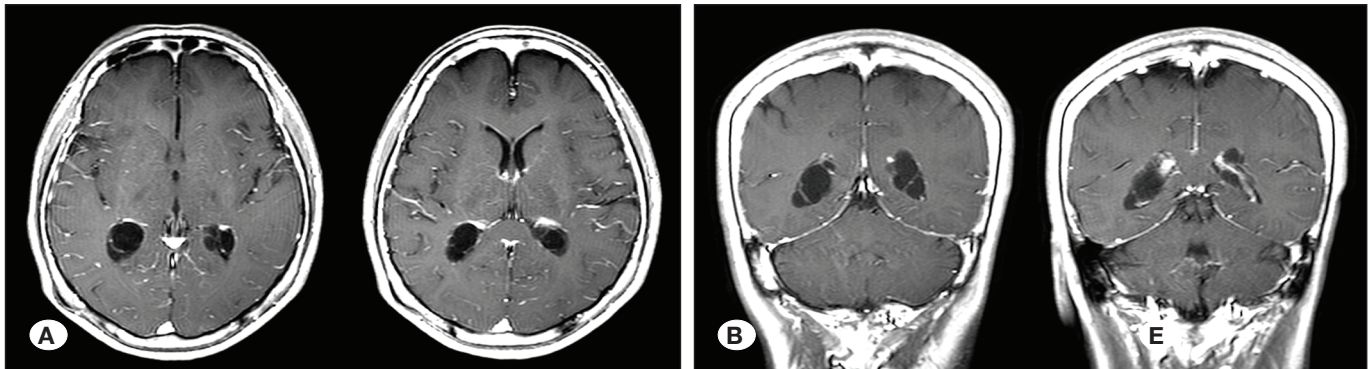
Axial (A) and coronal (B) cranial magnetic resonance images showing about 2 cm sized bilateral choroid plexus cysts in the trigone of the lateral ventricles.
